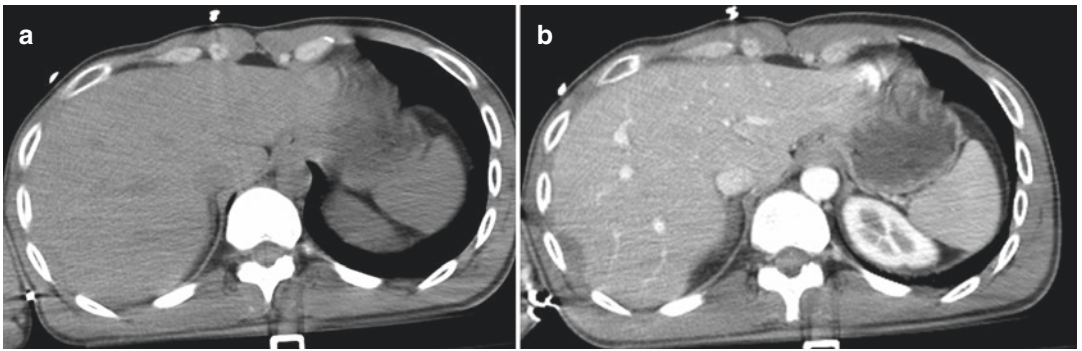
Male. Car accident. Subcapsular hepatic hematoma. (a) Nonenhanced CT shows a slightly hyperdense subcapsular hepatic area. (b) Contrast-enhanced CT depicts well the same zone as a subcapsular hepatic hematoma
